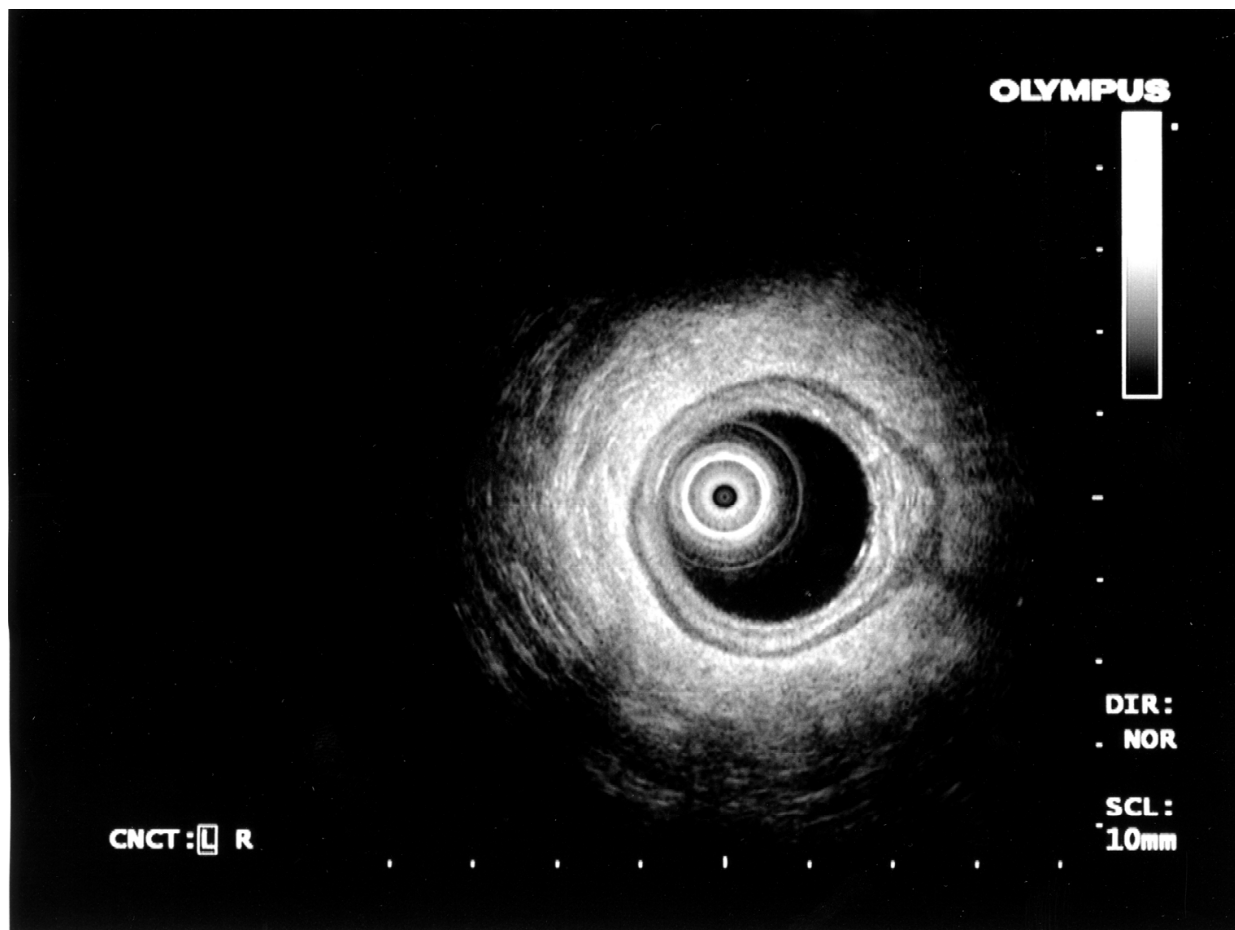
(B) Endorectal ultrasonographic images of the normal rectal anatomy
